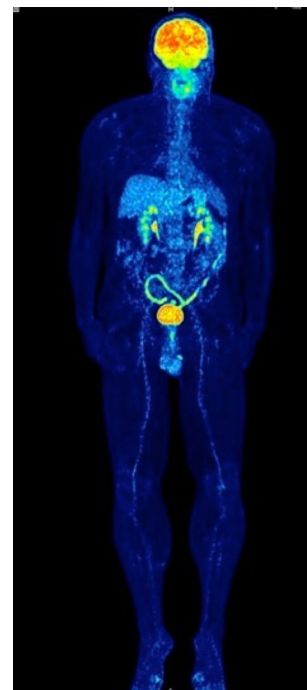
MIP image of a patient with colitis in ^{18}F -FDG following ipilimumab treatment. Note the enhanced ^{18}F -FDG uptake in the colon descendens, sigmoid and rectum
